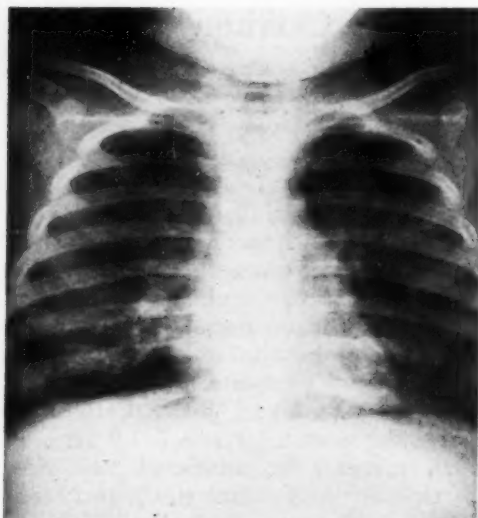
Earliest radiograph taken after ingestion of kerosene. The patient was a 16-month-old child found coughing and gagging beside a small can containing kerosene; dyspneic but not cyanotic. The film was taken about twenty-five minutes after the accident. Note small patchy areas of cloud-like density in both lower lung fields, more prominent on the right.
